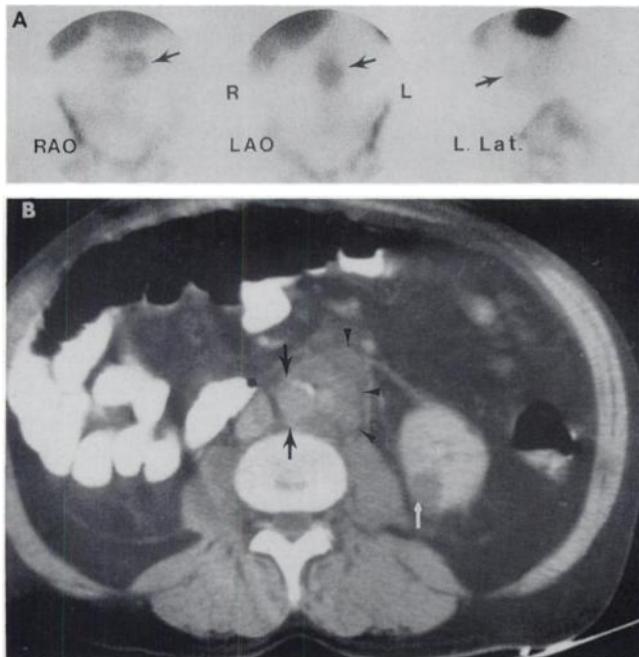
A 66-yr-old man (Patient 1) with coronary artery disease, fever, night sweats, low back pain and positive blood cultures. (A) Right anterior oblique (RAO), left anterior oblique (LAO) and left lateral (L. Lat.) WBC images reveal focal uptake in the left mid-abdomen (arrow). (B) CT scan shows a calcified aortic aneurysm (arrows) with an adjacent periaortic soft-tissue mass (arrowheads). Note simple cyst in adjacent left kidney (white arrow). A dissecting mycotic aneurysm with an adjacent infected hematoma was found at surgery.
